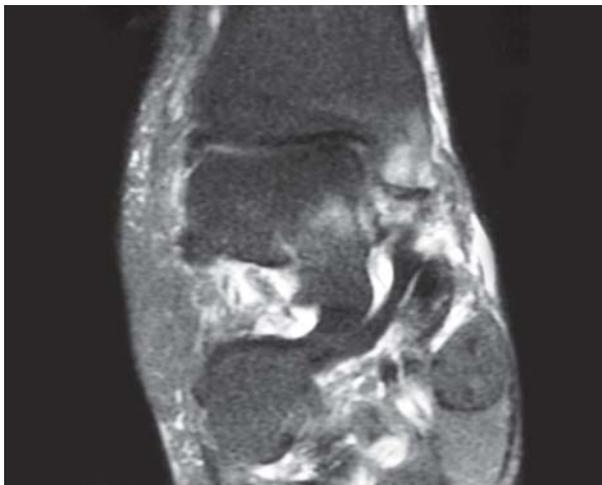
T2-weighted MRI showing high signal in the medial malleolus
